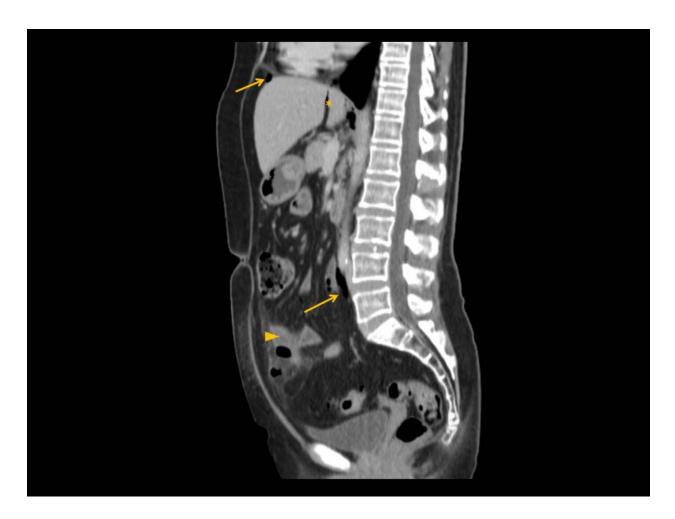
Sagittal CT images from same patient as Fig. 5. Note the free intraperitoneal gas along the mesentery to the fissure of the ligamentum venosum (*) and the mesenteric stranding (arrowhead) seen in diverticulitis.
